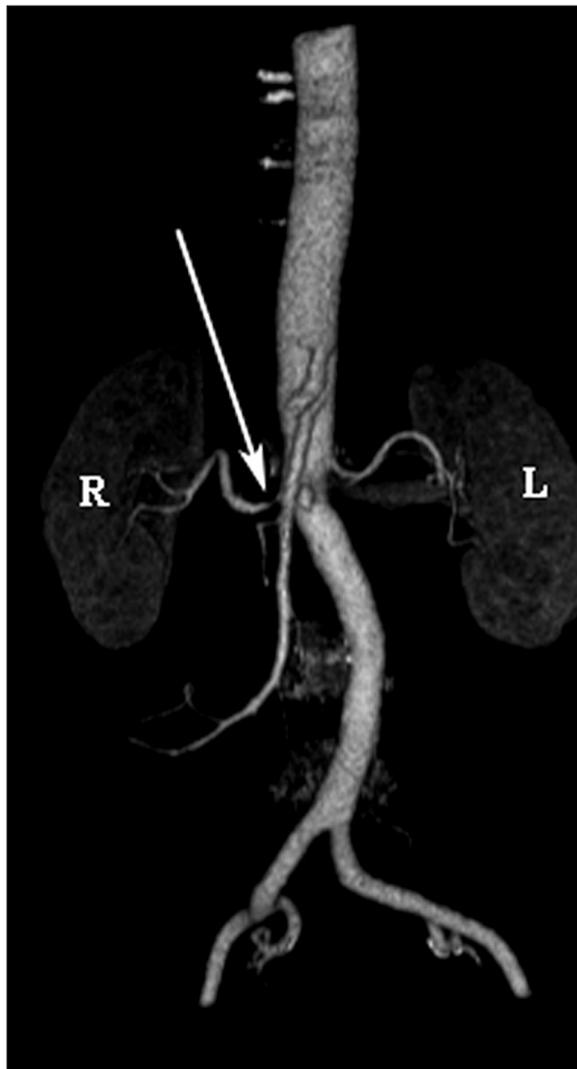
Computed tomographic angiography of a 68-year-old woman with progressively difficult-to-treat hypertension. A high-grade proximal right renal artery stenosis (arrow) was found. Although not “curative” of hypertension, balloon dilation and stenting of the lesion resulted in a reduction in blood pressure medications and dosages.
